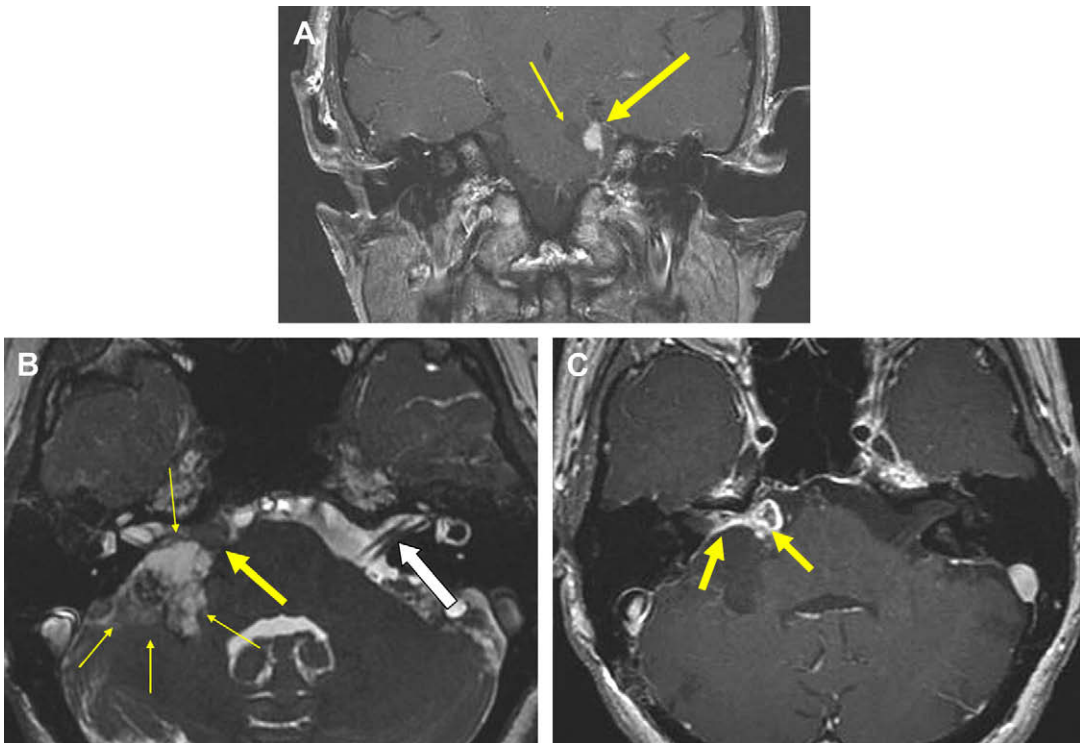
(A) Coronal postcontrast T1-weighted image in patient following RS surgery for AN removal. There is an enhancing mass (*thick yellow arrow*) adherent to the prepontine segment of the trigeminal nerve. Note brainstem encephalomalacia adjacent (*thin arrow*). The tumor was left intentionally to spare CN5 and had been stable in size for 36 months. (B) Axial T2* FIESTA image during a 6-month baseline postoperative examination. Tumor was left adherent to CN7 at the time of surgery to spare the nerve. Note the cerebellar encephalomalacia, hemorrhagic residua, and stranding of soft tissue interspersed with CSF along the right cerebellar margin (*thin yellow arrows*). There is soft tissue anteriorly (*thick yellow arrow*) with poor definition of CN7 and CN8. Note the normal appearance of CN7 and CN8 on the left (*white arrow*). (C) Axial T1 postcontrast image at the same level and time as B. There is enhancement of residual tumor (*arrows*) extending from the brainstem to the widened porous. CN7 cannot be clearly identified.
